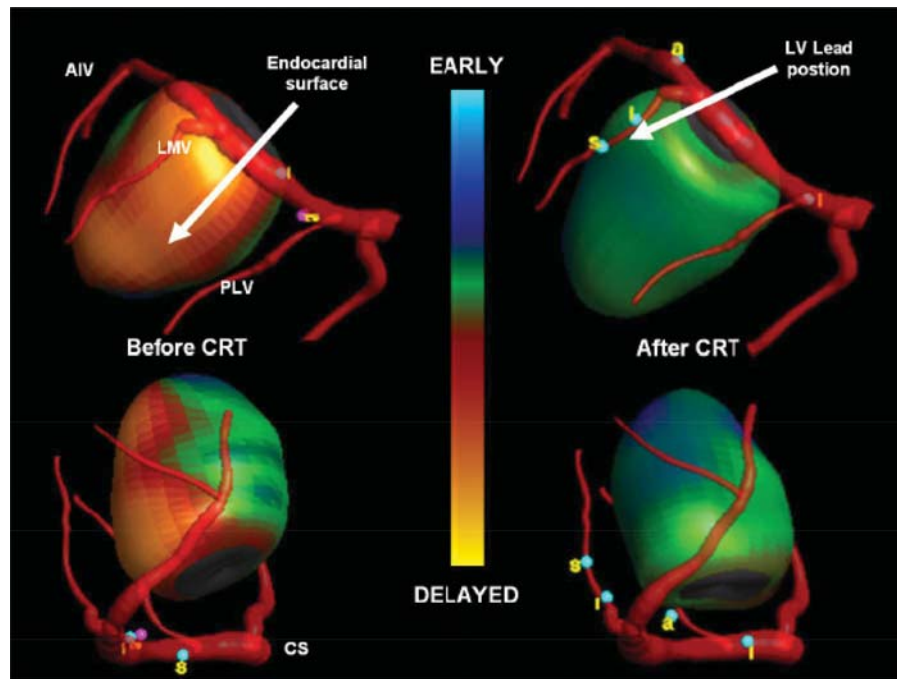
Image integration of the coronary venous anatomy with the segment of mechanical dyssynchrony. The image shows the integrated image of the reconstructed coronary veins and the mechanical dyssynchrony pattern using tissue Doppler imaging with three-dimensional echocardiography. There is a complete change in the dyssynchrony pattern (reduced) after cardiac resynchronization therapy with the left ventricular lead located along the lateral wall, mid-ventricular position (adapted from Tournoux *et al.*³⁵).
